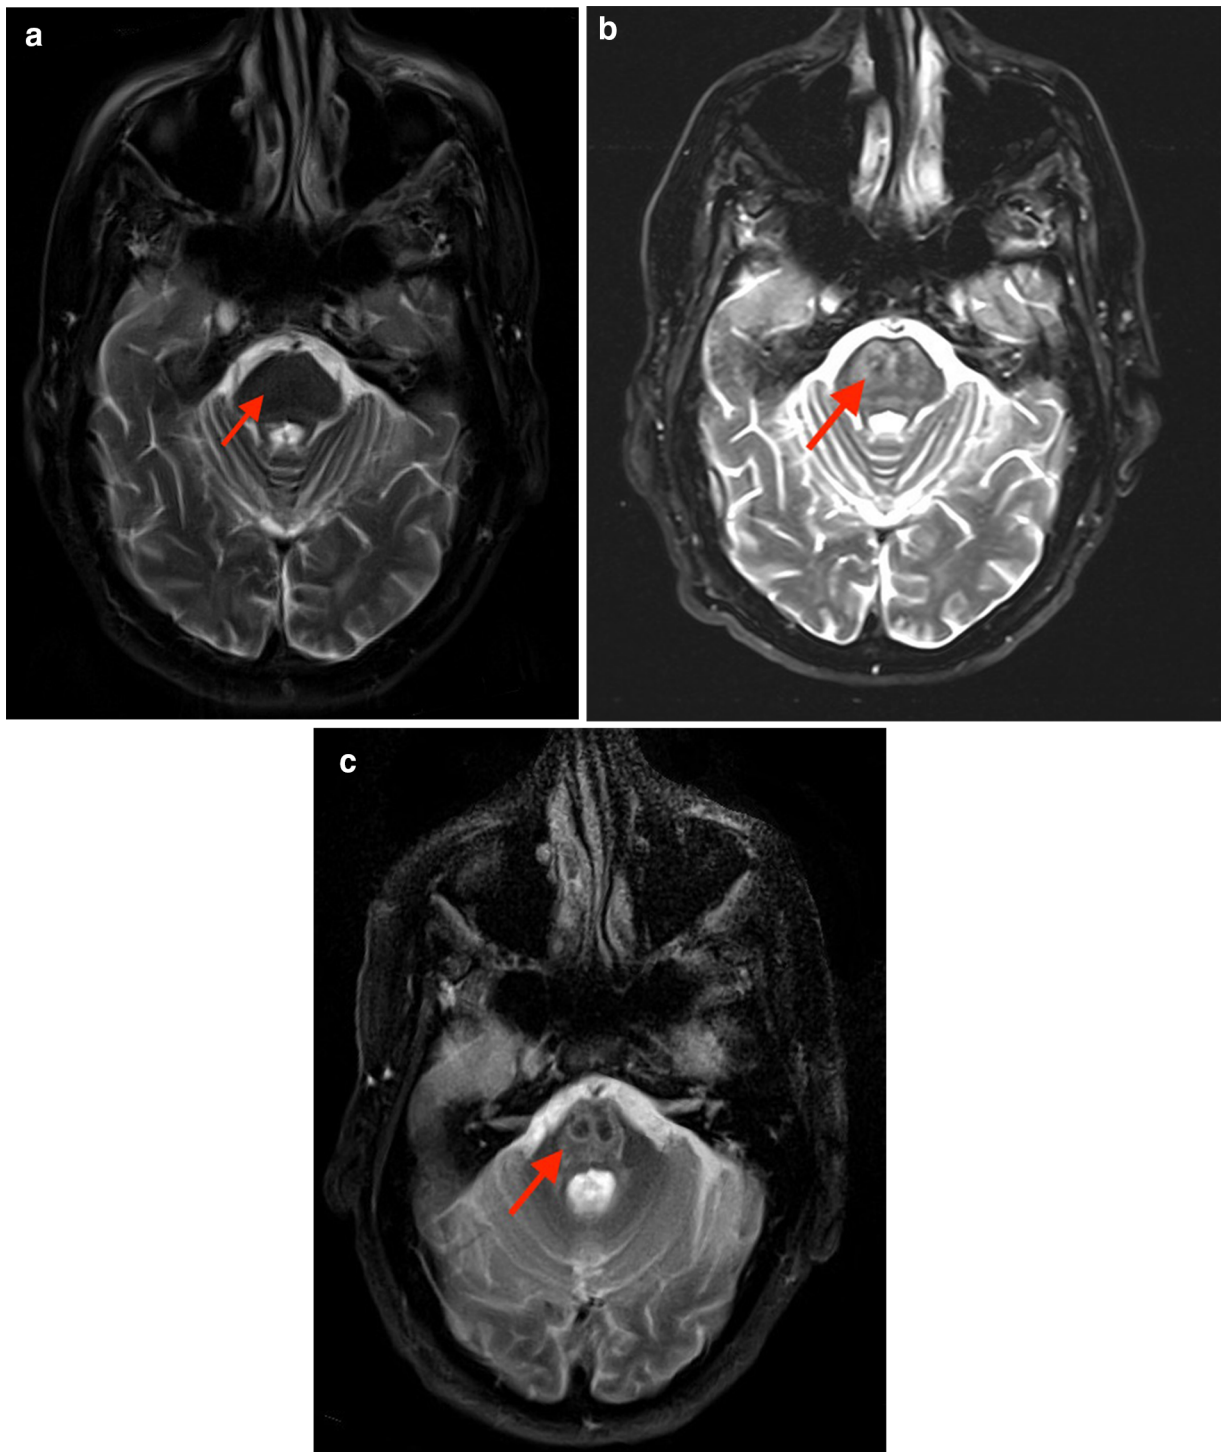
a Post symptom onset day 3. *MRI* normal T2 appearance of the central pons without evidence of hyperintensity. b Post symptom onset day 13. *MRI* confluent T2 hyperintensity in the central pons findings consistent with central pontine myelinolysis/osmotic demyelination syndrome, possibly subacute. c Approximately
